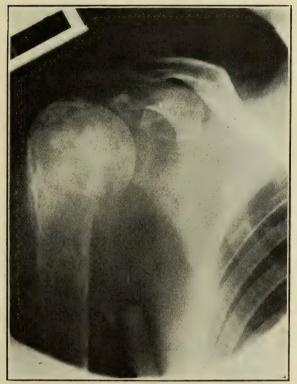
X-ray upon patient's second entrance to hospital, showing malignancy well developed.
